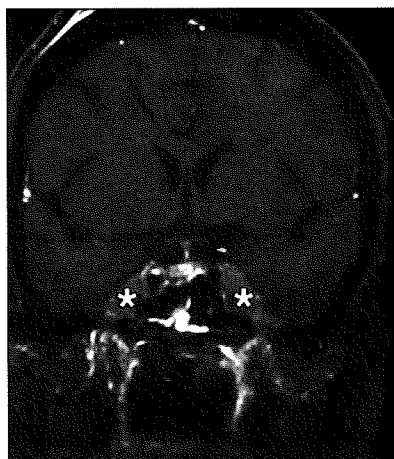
24-year-old woman with CNS infiltration of malignant lymphoma. Coronal contrast-enhanced T1-weighted MR image shows bilateral masses in Meckel's cave (*asterisks*) and left foramen ovale.
